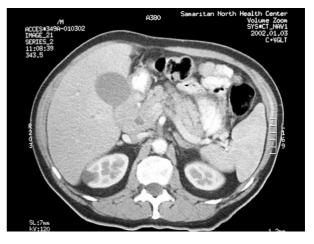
CT scan of mass showing duodenal compression with biliary obstruction.
